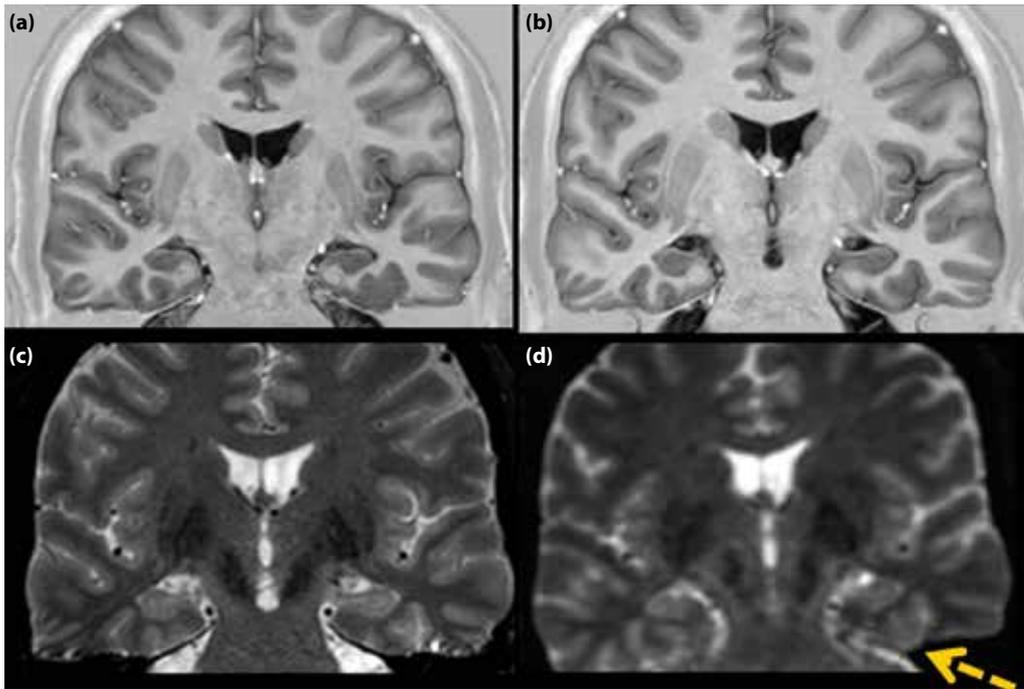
(a-d) T1 IR and T2WI MRI sequences showing subtle FCD in the left collateral sulcus.
